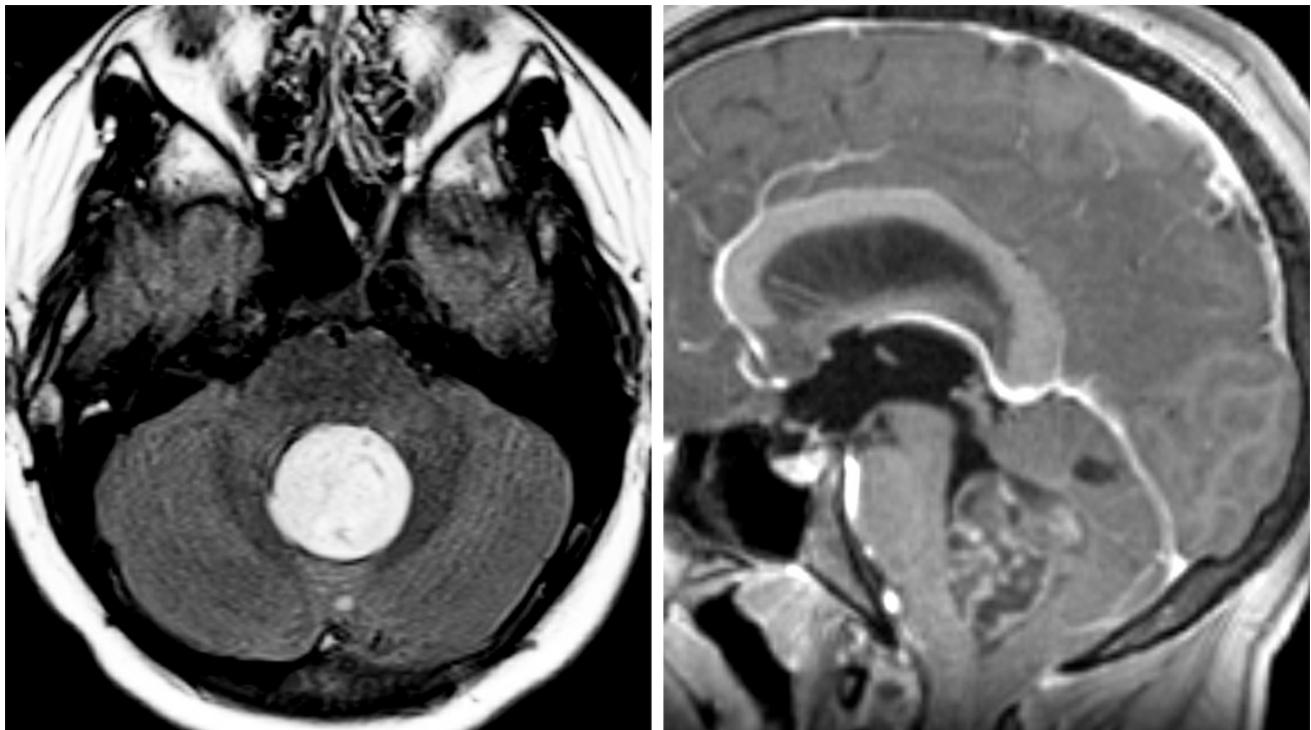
(Left) This mildly complex, circumscribed T2-FLAIR hyperintense rosette-forming glioneuronal tumor fills and expands the fourth ventricle, contributing to hydrocephalus in this patient, but causes little edema. (Right) The tumor demonstrates a heterogeneous internal pattern of enhancement.
